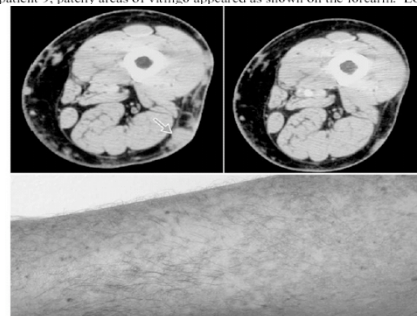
Antitumor and autoimmune manifestations following the transfer of lymphocytes with anti-MART-1 reactivity. Upper: CT scan of the lower extremity of patient 9 showing multiple melanoma metastases (arrow) in the skin and subcutaneous tissue (left) that underwent regression (right) after cell transfer. Middle: As cancer regressed in the lower extremity of patient 9, patchy areas of vitiligo appeared as shown on the forearm. Lower: Two
